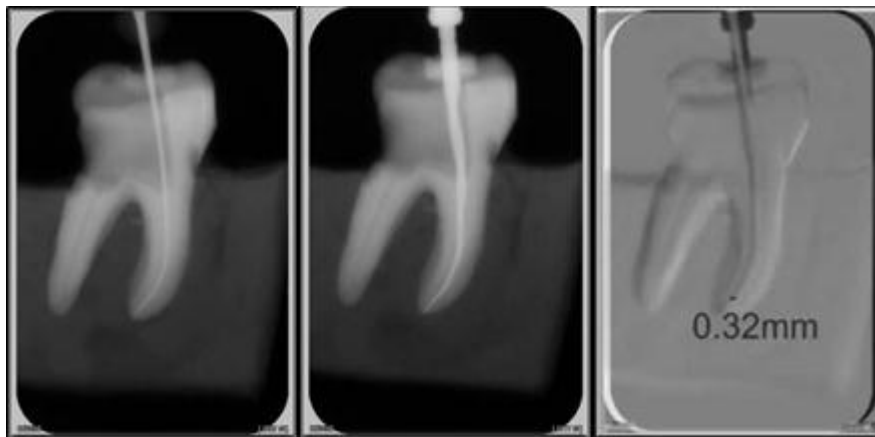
Super-imposition of Pre and Post Instrumentation Radiographs
